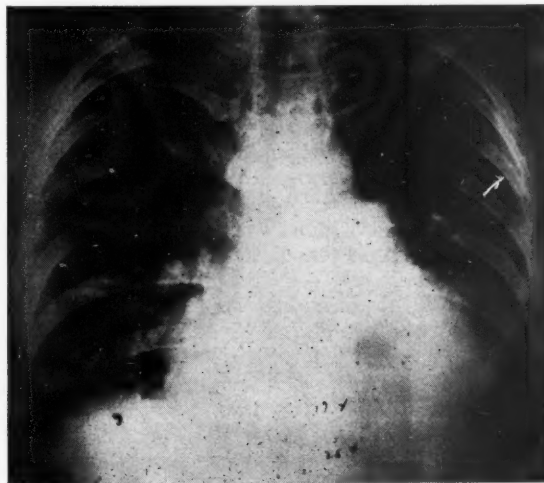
The chest x-ray film reveals changes indicative of passive congestion in both lung bases, with over-all increase in heart size and left ventricular enlargement.
